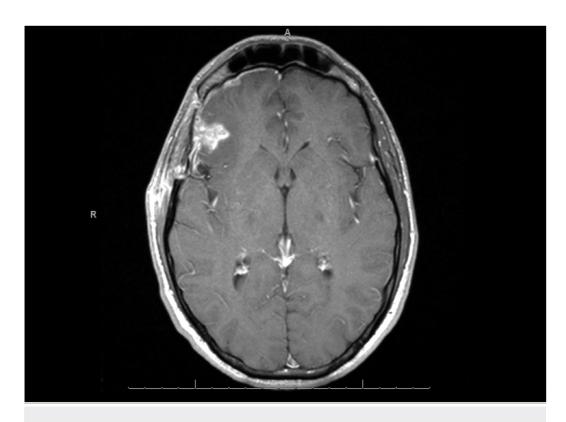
MRI One Month Post-Resection
